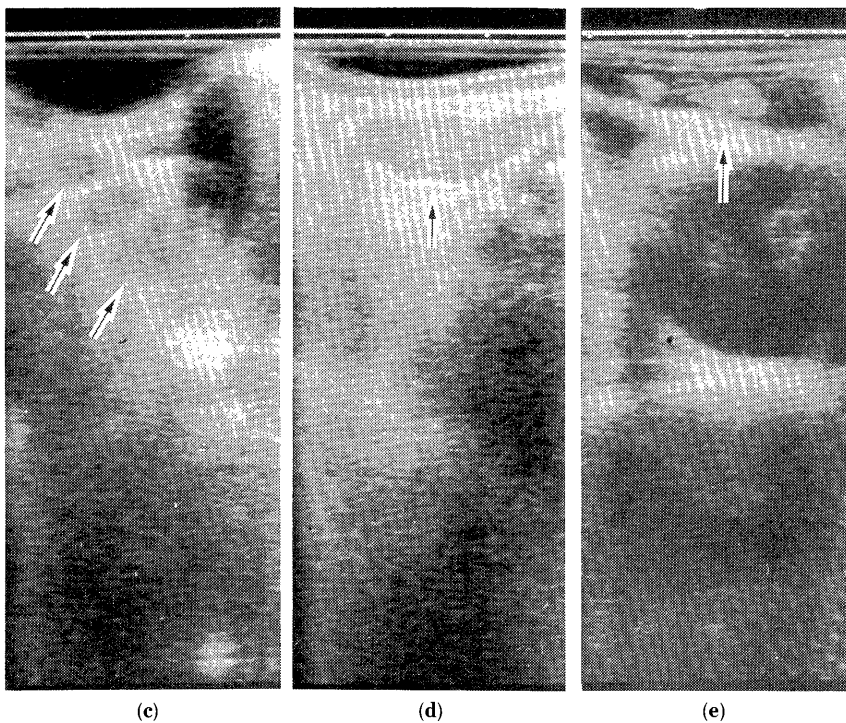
Endoscopic ultrasonograms of non-metastatic lymph nodes showed dull and weak echo of boundaries (c), high intensity of internal echo (d), and diffuse and homogeneous pattern (d), or high echoic nodule (e) of internal texture.
